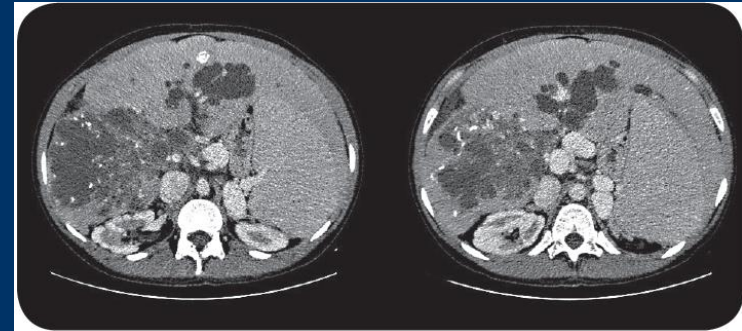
Abdominal computed tomography scan showing multiple diffuse cysts in the liver with peripheral calcifications, affecting the hepatic hilum and both hepatic lobes.
